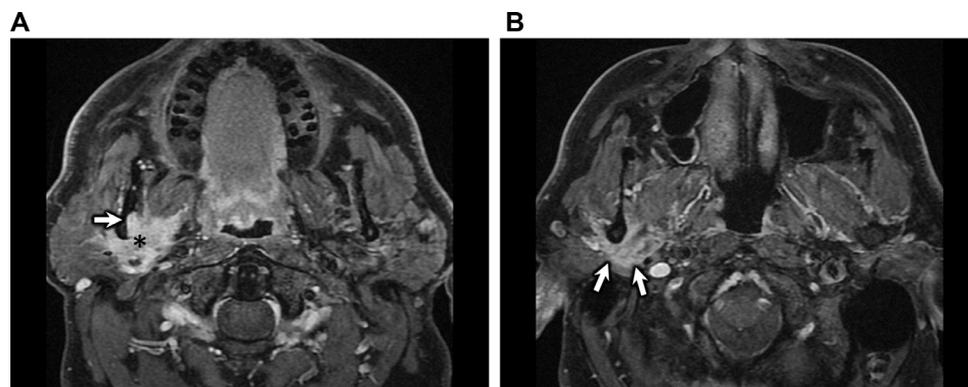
Perineural tumor spread involving the auriculotemporal nerve from deep parotid adenoid cystic carcinoma. (A) Axial T1-weighted postcontrast fat-saturated image shows an enhancing surgically-proven adenoid cystic carcinoma arising from the deep lobe of the right parotid gland (black asterisk). There is perineural tumor spread along the right inferior alveolar nerve widening the mandibular foramen (white arrow). (B) Axial T1-weighted postcontrast fat-saturated image shows perineural tumor spread along the characteristic course of the right auriculotemporal nerve (white arrows) which is abnormally enlarged and enhancing, extending through the right stylomandibular tunnel and coursing posteriorly to the right mandibular ramus.
